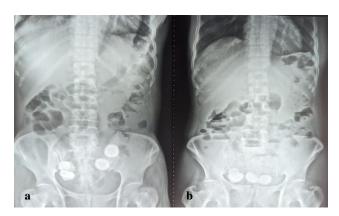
(a and b): X-ray abdomen showing foreign bodies with features of small bowel obstruction.
